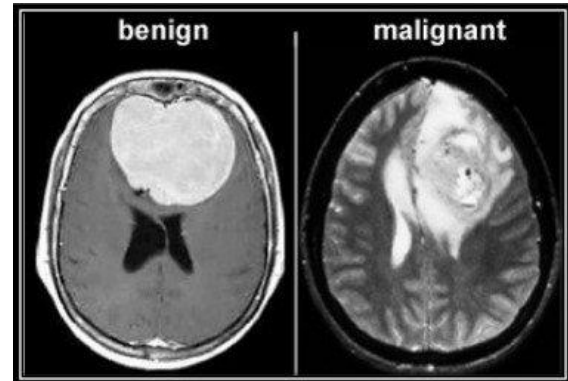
Nasim, et al., (2019), MRI scans of two brains (left; benign/non-cancerous, right; malignant/cancerous)
